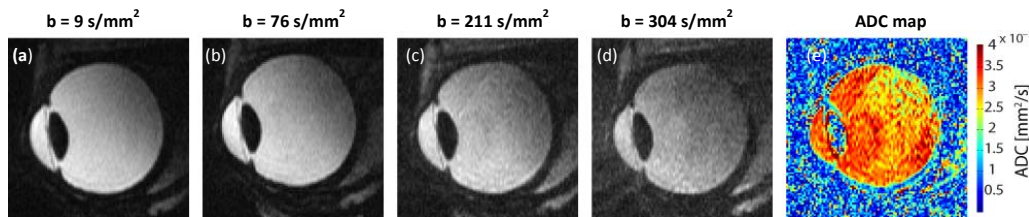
DWI of the eye at 7 T. (a)-(d) Diffusion weighted images of the eye obtained with segmented DWI-RARE using b-values ranging from 9 s/mm^2 to 304 s/mm^2 . (e) ADC map calculated from the diffusion weighted images.
